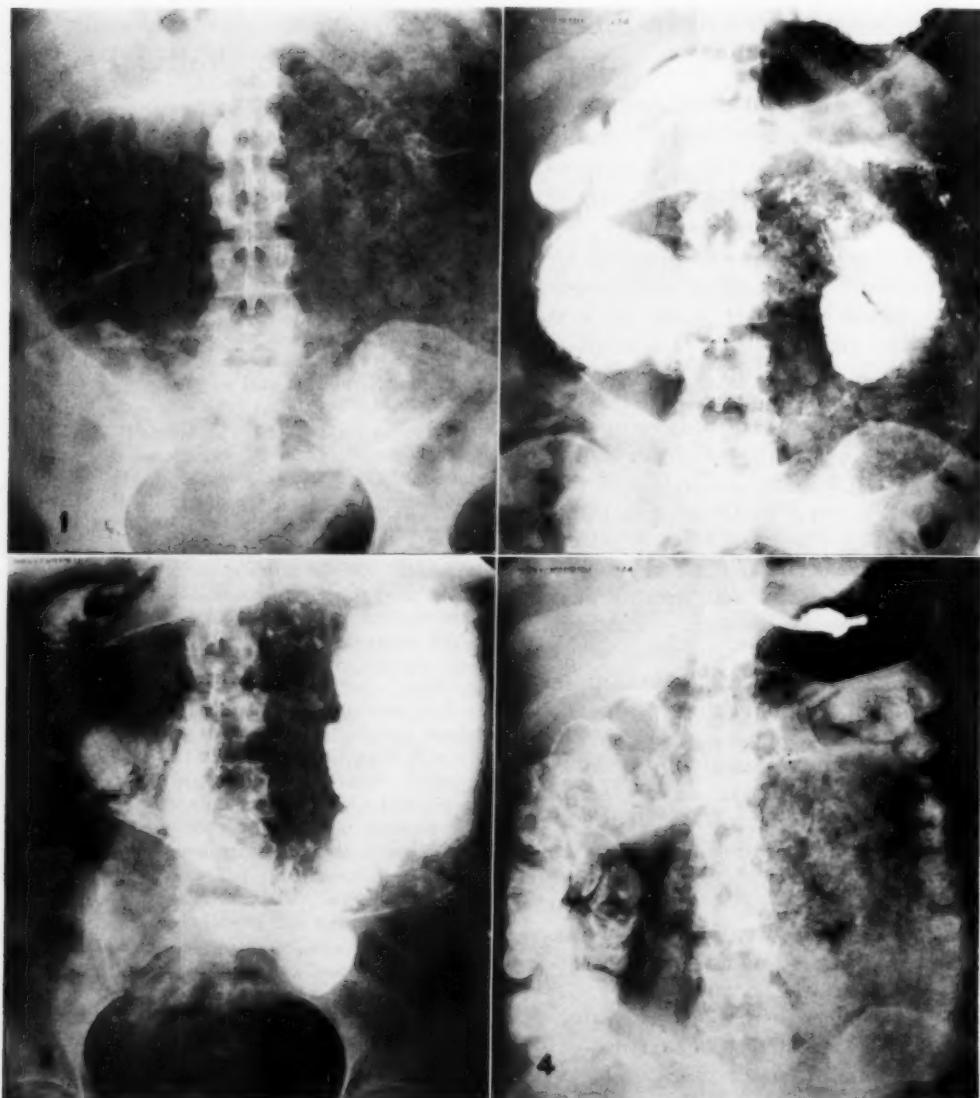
Initial plain roentgenogram of the abdomen demonstrating a large amount of gas in what appeared to be a hollow viscus.
